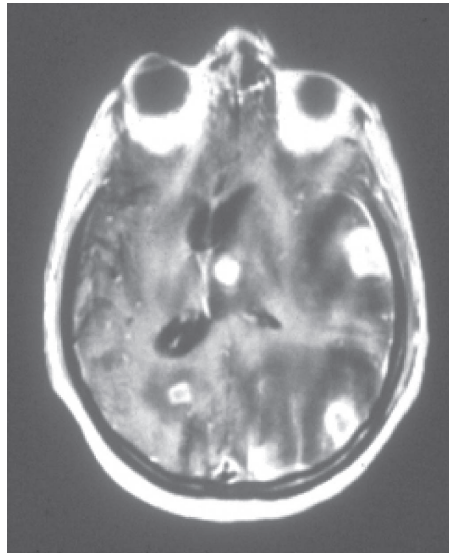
MRI scan of the brain showing multiple mass lesions with surrounding oedema and midline shift. The mass lesions show ring enhancement with contrast. Typical appearance of cerebral toxoplasmosis.
